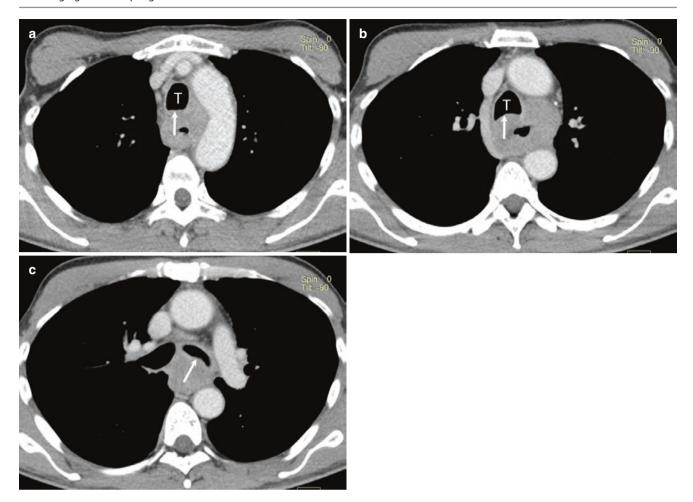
Airway involvement but sparing of the aorta. (a–c) Axial CT images show an upper-mid-esophageal mass with bowing of the posterior tracheal wall and projecting in the left main bronchus suggesting airway involvement (arrow). Aorta is not involved. *T* trachea
